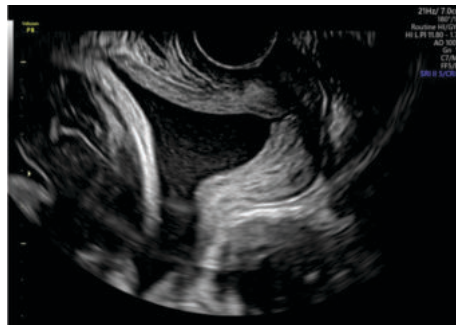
Short cervical length with open internal os on transvaginal sonography (TVS)
